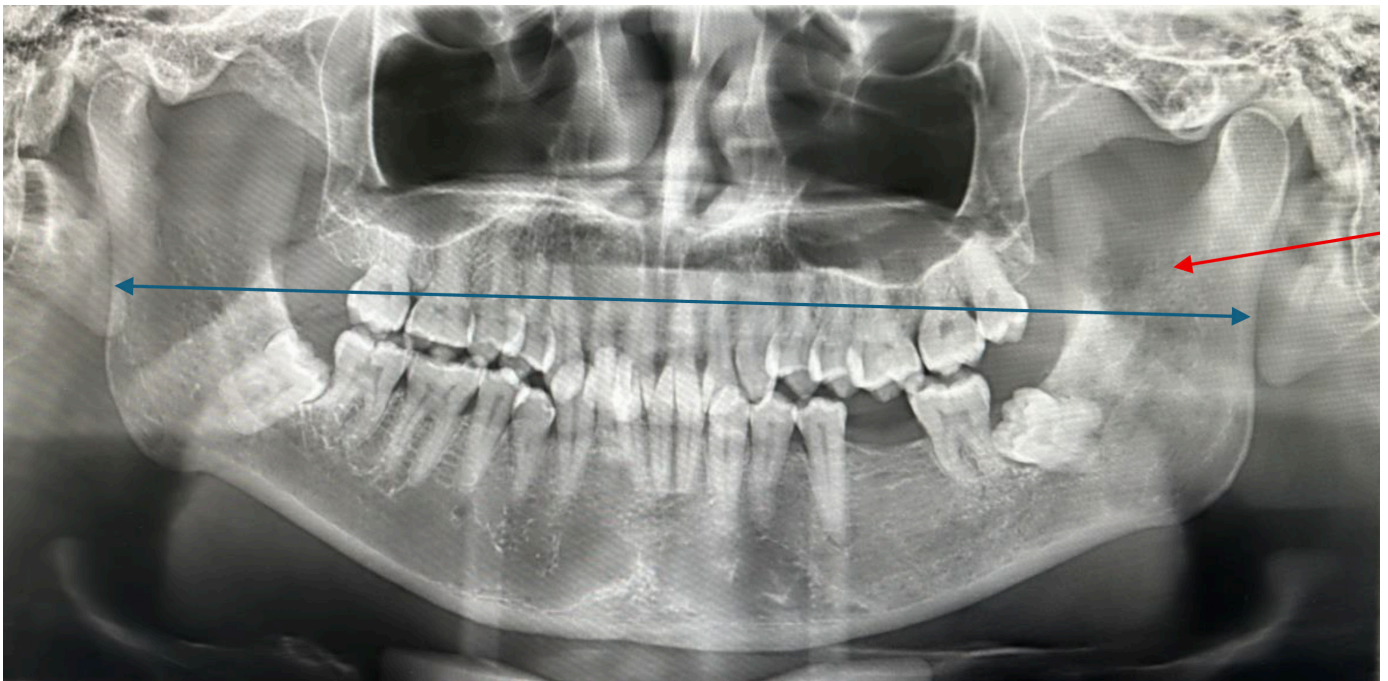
The Orthopantomograph taken at the initial consultation with the OMS team shows an ill-defined radiolucency inferior to the left sigmoid notch and the base of the coronoid process (red arrow). The blue double-headed arrow represents the level of the axial CT slice, shown in Figure 2.
